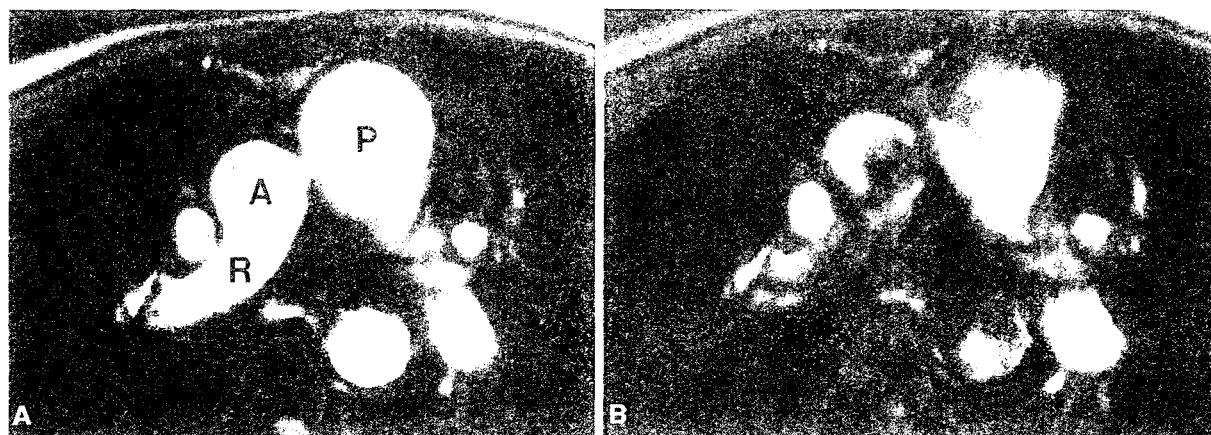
Case 3. A Axial image of a cine MRI along the plane of the right pulmonary artery during systole clearly showing the anomalous origin of the right pulmonary artery (R) from the posterior aspect of the ascending aorta (A). Note that the main pulmonary artery (P) is
